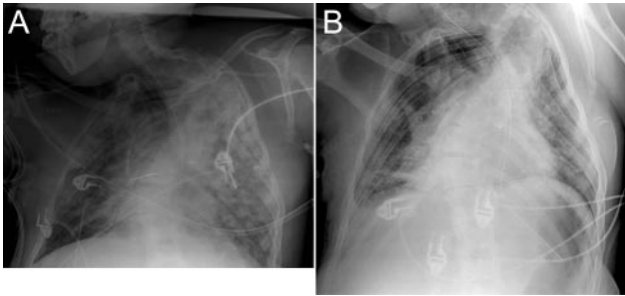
A: At admission in the ICU. B: At day 13 after admission the chest x-ray revealed diffuse and bilateral alveolar infiltrates.
